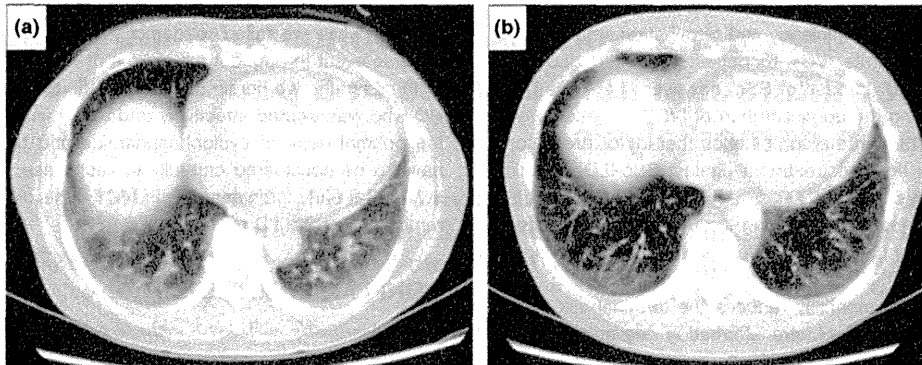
High-resolution computed tomography (HRCT) scan before and after intravenous cyclophosphamide pulse (IVCY). (a) HRCT in November 2009. Before IVCY, the lungs revealed early bibasilar interstitial changes. (b) HRCT in October 2010. After IVCY, the image revealed a remarkable resolution of ILD.
